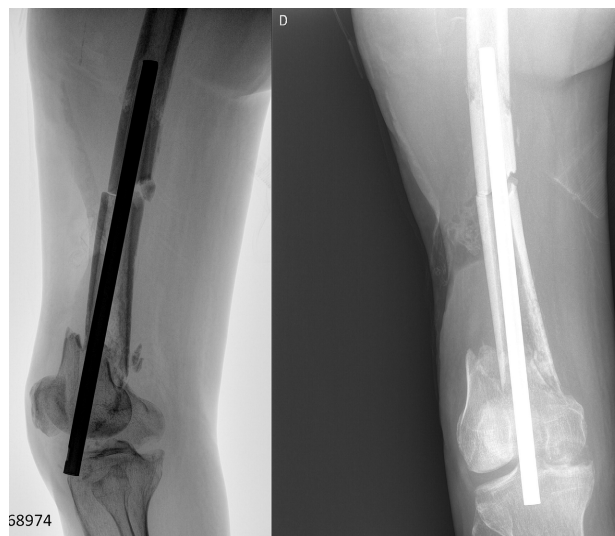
Case no. 3. Radiographs after removal of all implants. Placement of a pelvo-tibial spanning external fixator.
